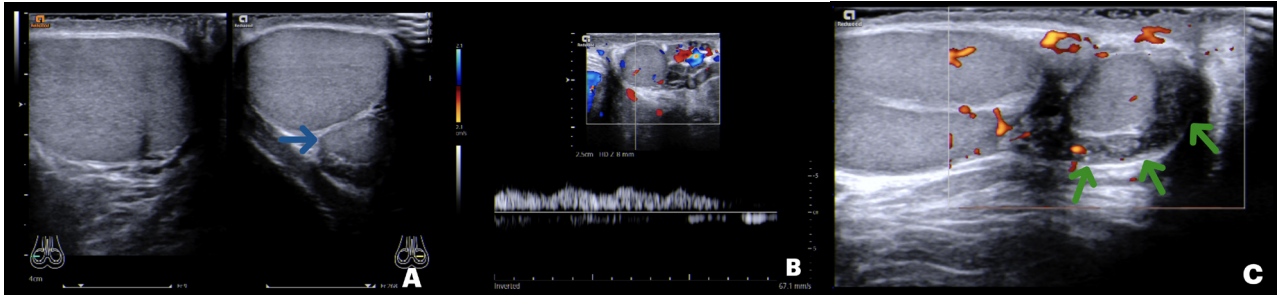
Triorchidism. Doppler ultrasonography images show one testicle in the right scrotal sac and two testicles in the left scrotal sac, the smaller one corresponding to a supernumerary testicle (blue arrow) (A). The supernumerary testicle has morphology, echotexture, and vascularization similar to the primary testicles (B). The epididymis of the supernumerary testicle (green arrows) is enlarged, suggesting epididymitis (C).
